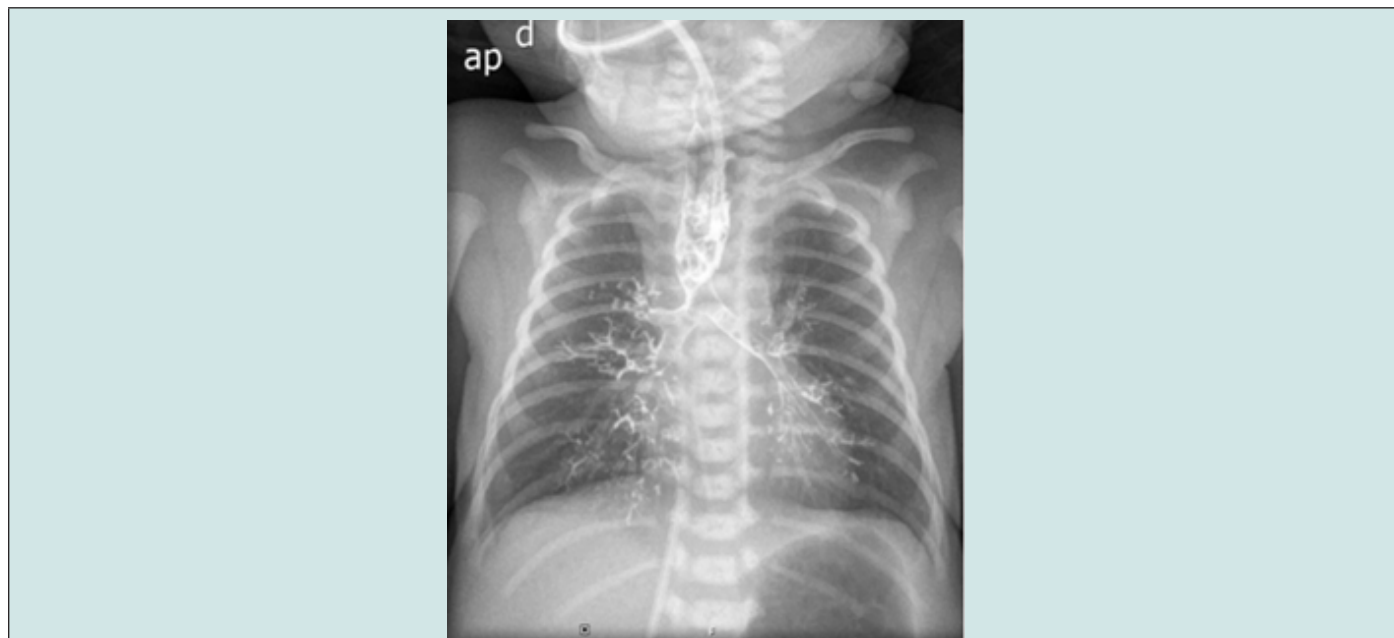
Antero-posterior x-ray and esophagogram with water-soluble agent demonstrating EA. Dilated proximal esophageal pouch. A distal fistula is suspected due to the presence of gas in the stomach.
